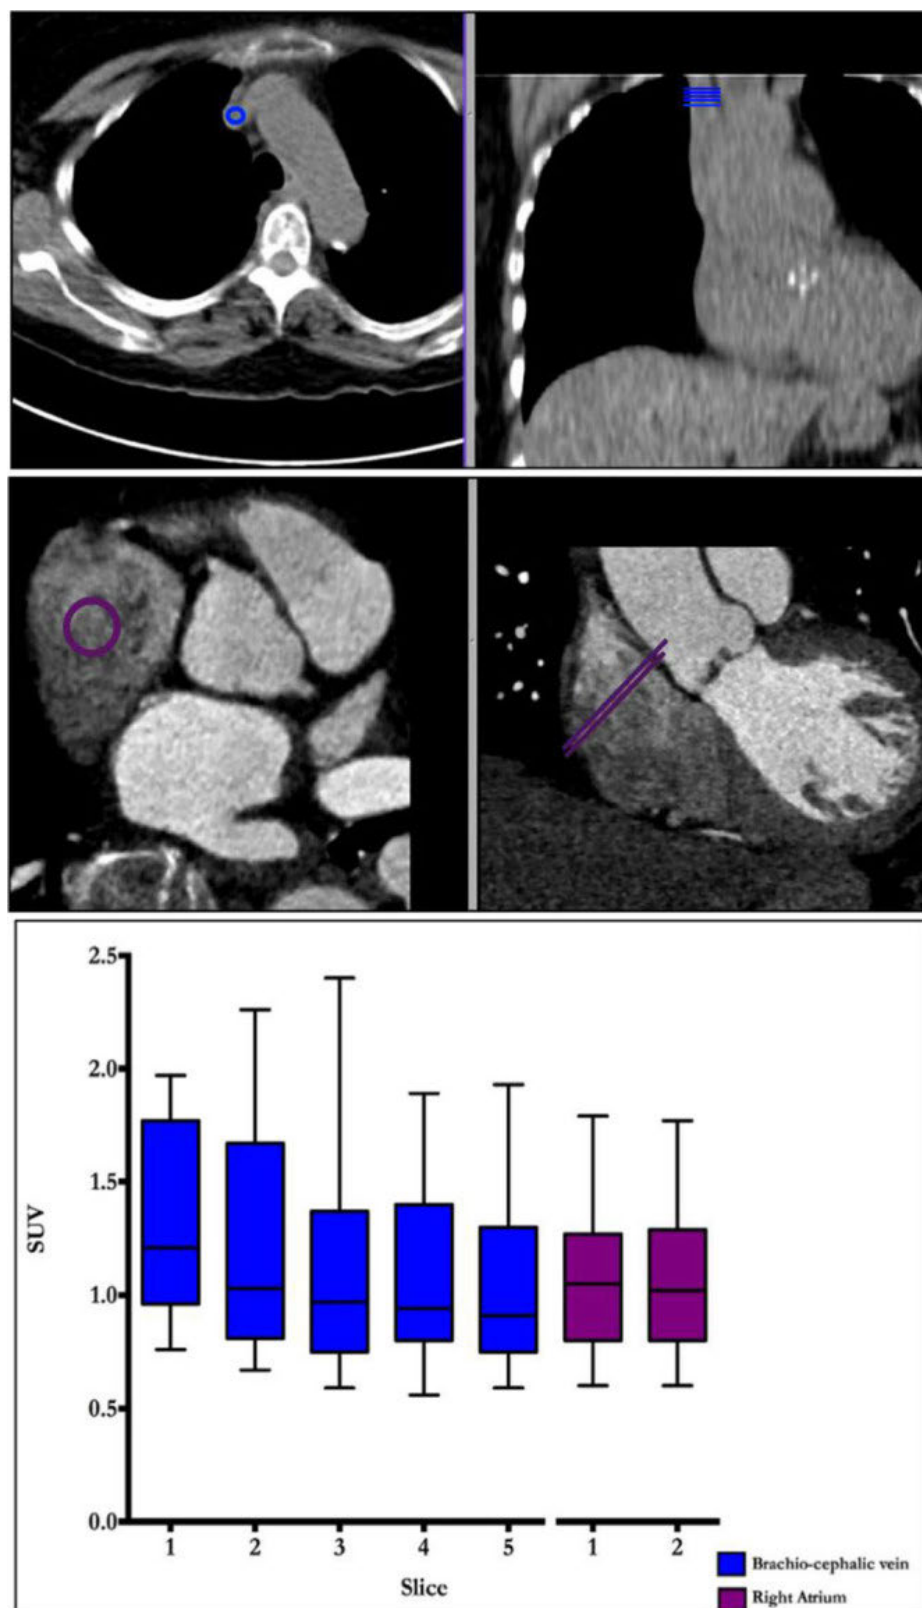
Regions of interest for measuring blood pool activity in the brachiocephalic vein (top) and right atrium (bottom) are shown in the en-face of the valve (left) and coronal (right) planes. Note that the right atrium is a much larger structure allowing for larger regions of interest with less potential for partial volume artifact problems related to poor registration. Tukey plot demonstrates mean SUV values for 5 contiguous slices from brachiocephalic (blue) and 2 from the right atrium (purple). Note the variation in brachiocephalic vein measurements between those taken most caudally versus those taken most cranially.
